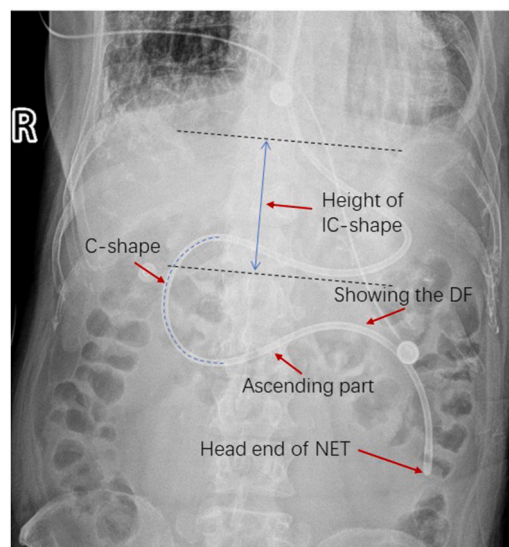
NET's configuration under the abdominal radiography. The blue color double arrow solid line indicates the height of the IC-shape, its apex being the horizontal line through the cardia, and its lowest point being the horizontal line through the NET at the lower edge of in the stomach (theoretically equal to the level of the lower edge of the stomach). The blue dashed line indicates the C-shape, which theoretically represents the duodenal bulb, descending part, and horizontal part. IC-shape, inverse C-shape; DF, duodenojejunal flexure; NET, nasointestinal tube.
